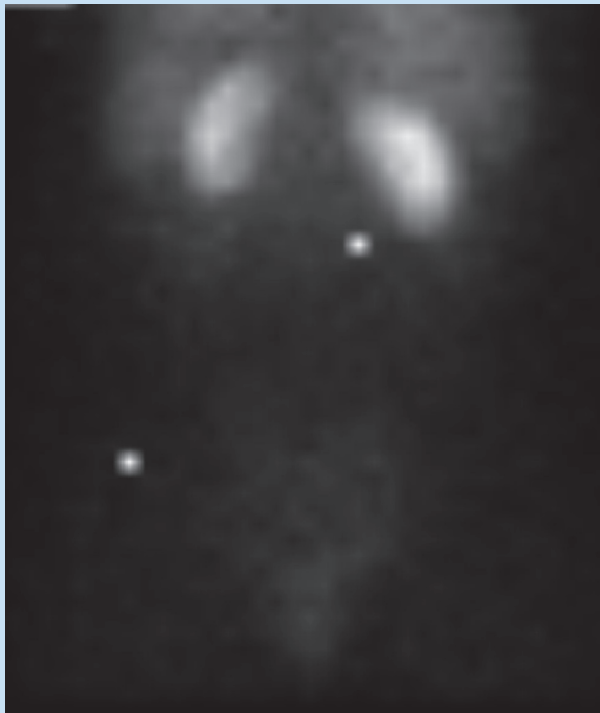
Tc-99m DTPA scintigraphy in coronal posterior-anterior view demonstrates that the left kidney is smaller than the right, but both kidneys demonstrate normal tracer uptake.
